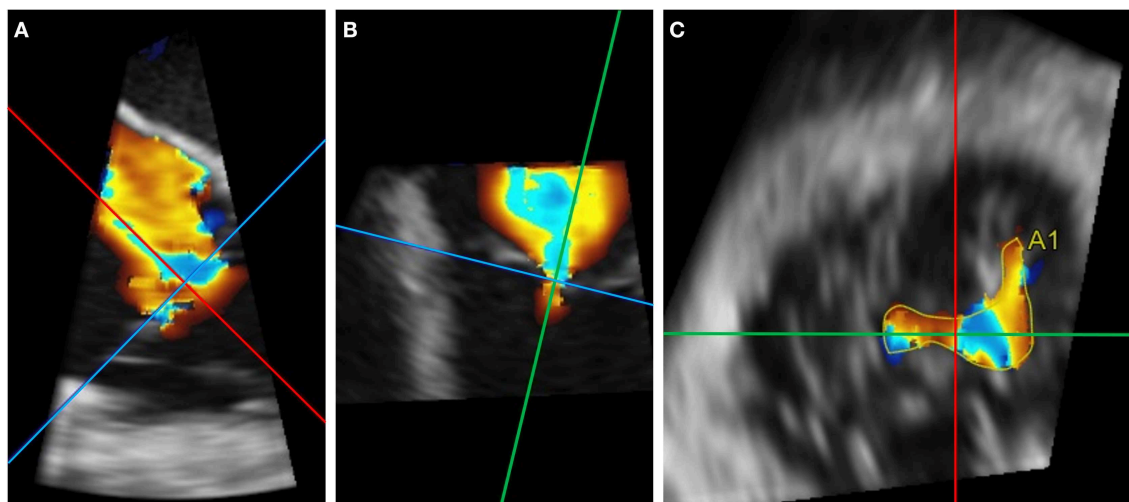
Example of 3D Doppler VC area using multiplanar reconstruction. (A,B) Reformation planes are aligned at the height of the 2D vena contracta during systole in two different planes. (C) A1 measures 1.65 cm² in this case.
